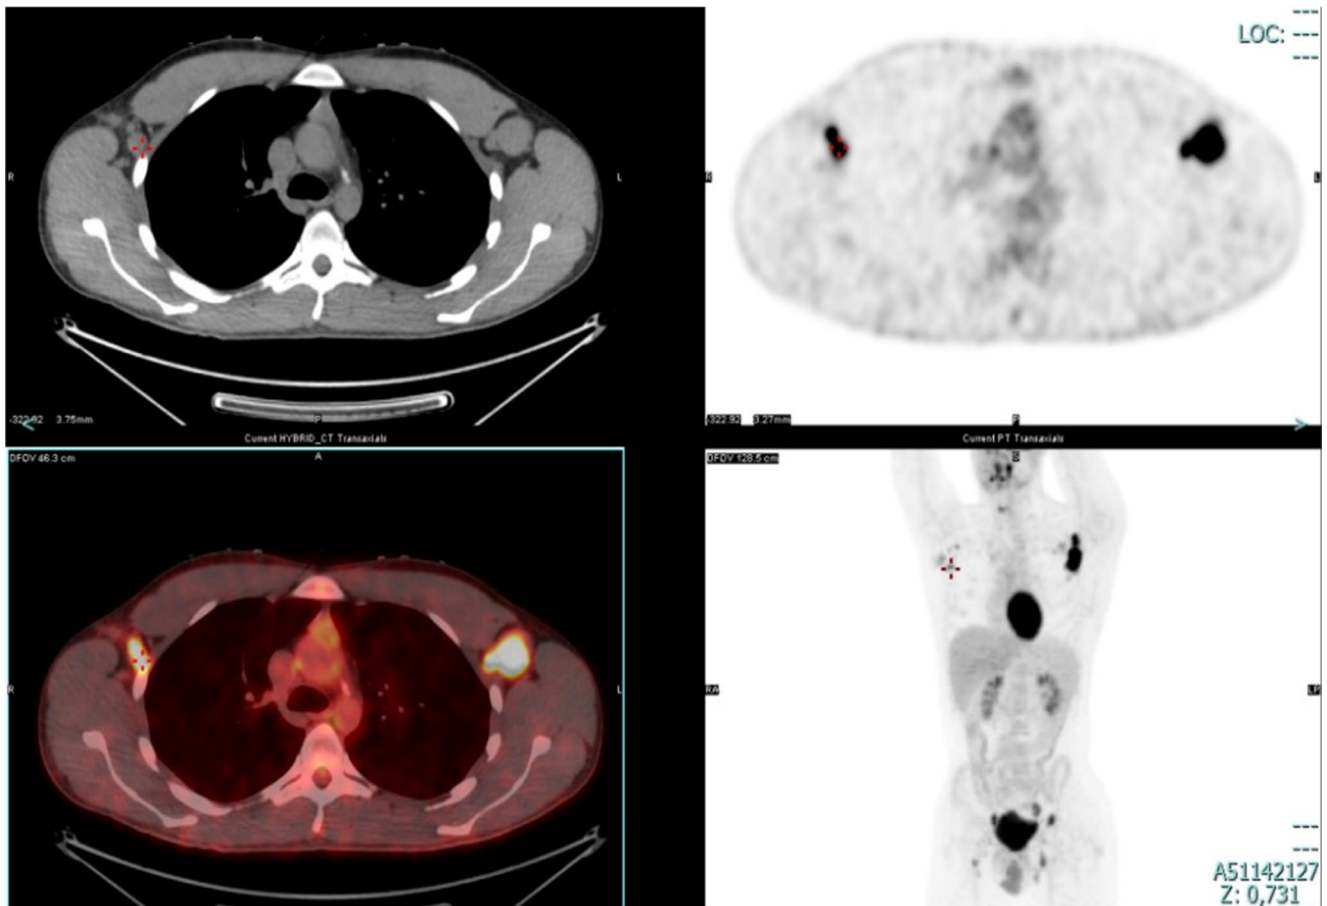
PET scan findings in a patient with common variable immunodeficiency developing nodular lymphocyte-predominant Hodgkin's lymphoma (maximum standardized uptake value [SUV] of 15 in the axillary lymphadenopathies)
